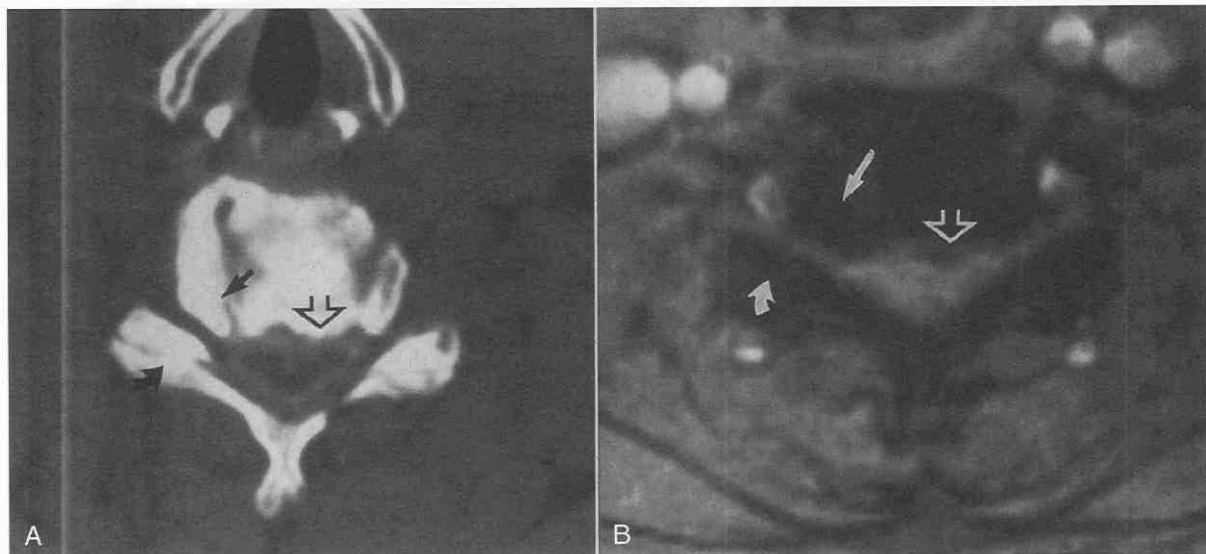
Postmyelogram CT scan (A) and axial gradient-echo (B) MR image show hypertrophied uncovertebral joint (closed arrows) narrowing the right neural foramen. Right-sided facet hypertrophy (curved arrows) contributes to this narrowing. Note also osteophytes (open arrows).
